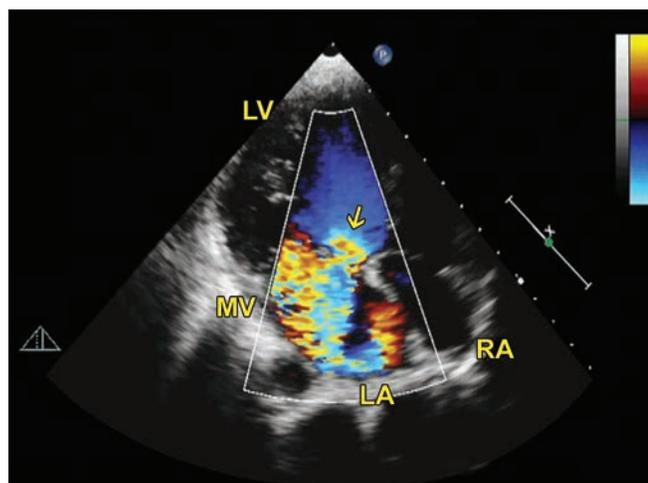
Color Doppler study demonstrating severe MR through the perforation (arrow) in the anterior MV leaflet.
